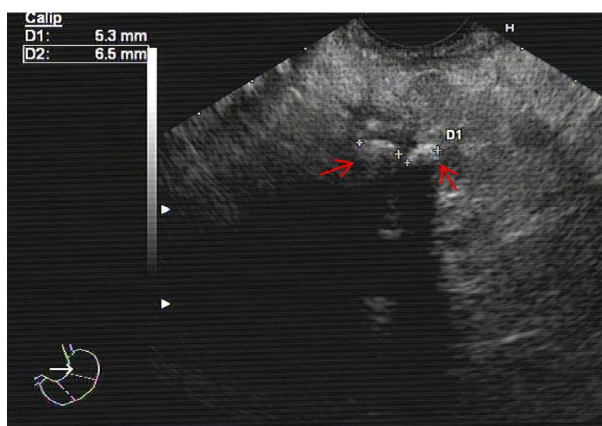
Presence of two lithiasis in the main pancreatic duct (arrows) visualized by endoscopic ultrasonography.
